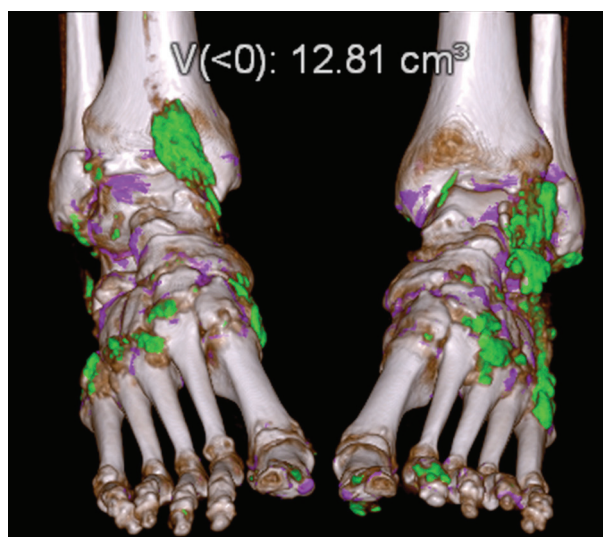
Dual-energy CT. Volume-rendered color-coded dual-energy image of ankles/feet showing urate deposits (depicted in green). Automated quantification of urate volume is displayed at the top of the image.
